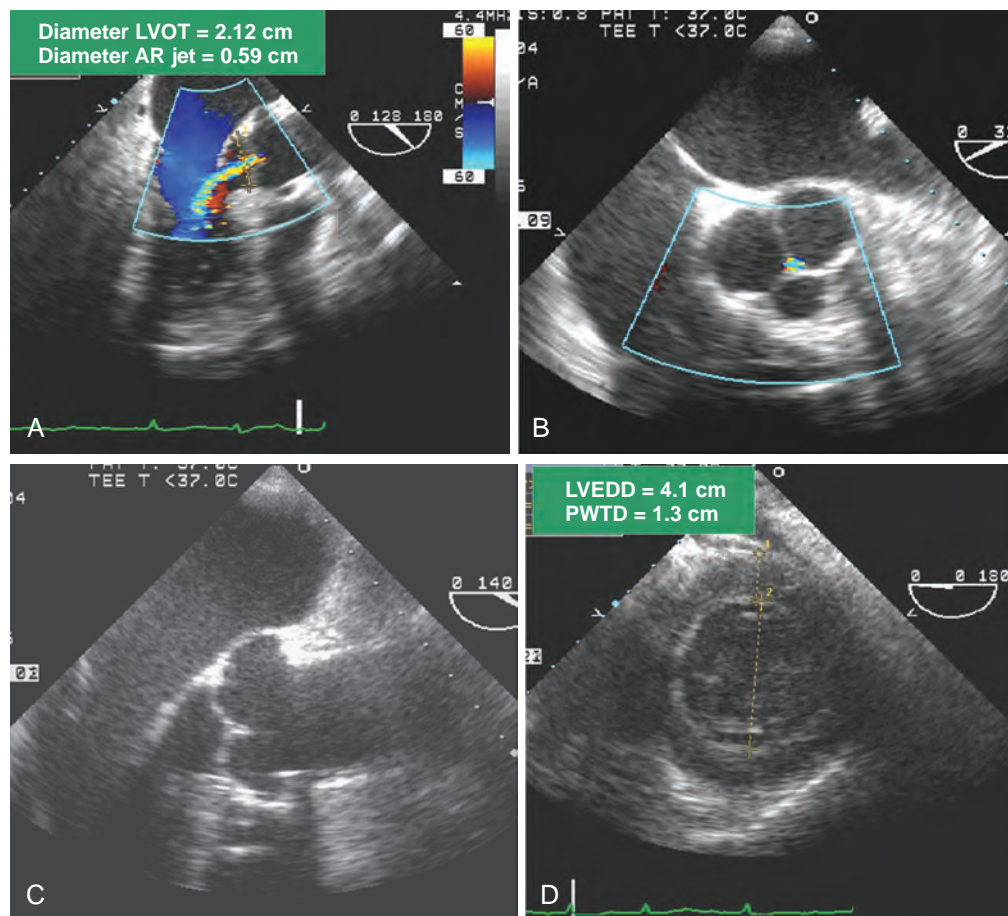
Detection of occult aortic regurgitation (AR) during a nonvalvular cardiac surgical procedure. A 66-year-old woman was scheduled to undergo coronary artery bypass grafting using extracorporeal circulatory support. (A) An intraoperative transesophageal echocardiography examination detected the presence of a central AR jet that extended halfway into the left ventricle. The severity of AR, which was graded as mild, was based on assessing the retrograde flow in the left ventricular (LV) outflow tract (LVOT) by using color-flow Doppler imaging in midesophageal long-axis plane. The severity of AR is determined by comparing the width of the AR jet, 0.59 cm, with the diameter of the LVOT, 2.12 cm; the ratio of 0.28 is graded as mild. (B) and (C) The anatomy of the valve was that of a normal trileaflet structure with mildly thickened leaflets. No leaflet prolapse, vegetations, or annular or root dilation was present. In addition, no significant aortic stenosis was detected by Doppler examination or calcification of the leaflets. (D) LV chamber size was normal, LV end-diastolic dimension (LVEDD) was 4.14 cm, and the presence of LV hypertrophy was consistent with hypertension. Because the severity of AR was not clinically significant and it was not expected to increase markedly, surgical intervention in the aortic valve was deferred. However, the diagnosis of AR altered circulatory management by increasing the vigilance of the echocardiographer to monitor LV chamber size during antegrade cardioplegia and initiate supplemental retrograde cardioplegia. PWTD, Pulsed-wave tissue Doppler.
